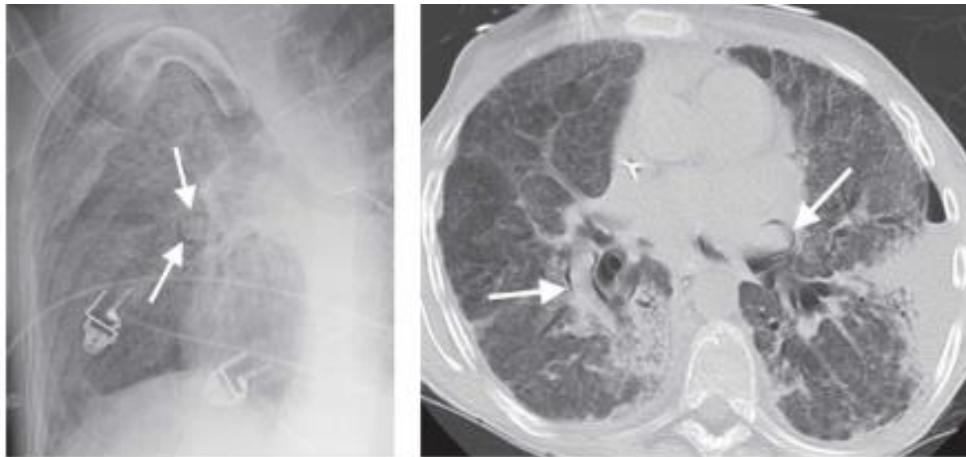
Ring around the artery sign. A: PA chest X-ray of a patient with acute respiratory distress syndrome showing a lucent ring around the right pulmonary artery (arrows) as a marker of pneumomediastinum. B: Thorax CT scan confirms air around both pulmonary arteries (arrows).^{1,2}
